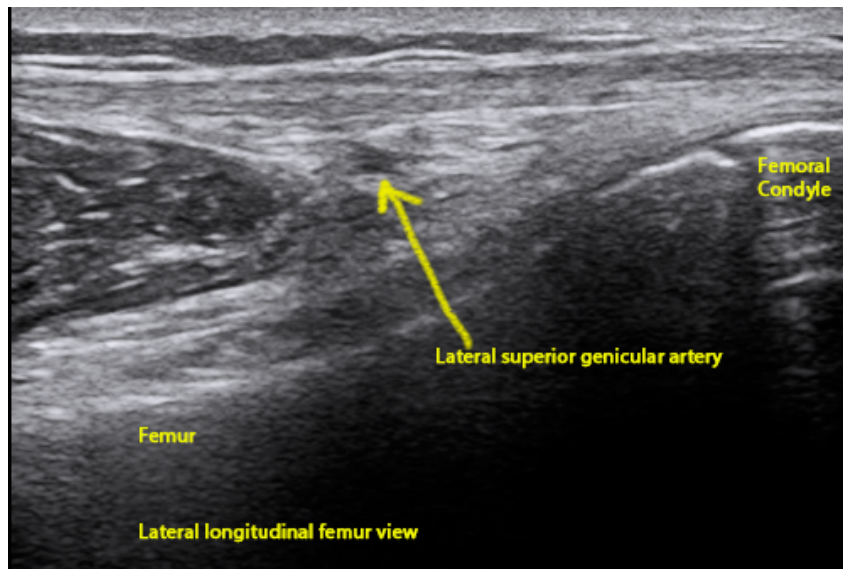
Longitudinal ultrasound image demonstrating the injection site for superior lateral genicular nerve block.
